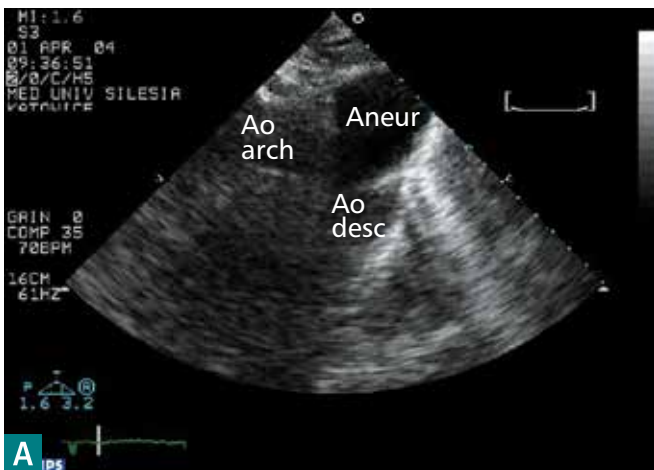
Transthoracic echocardiography. Suprasternal view. Panel A – Spherical aneurysm of the aortic arch (Aneur). Panel B. Outline of the aortic arch and the aneurysm. Panel C. Color Doppler ultrasound shows turbulent blood flow to the aneurysm during systole. Ao desc – descending aorta, Ao arch – aortic arch
